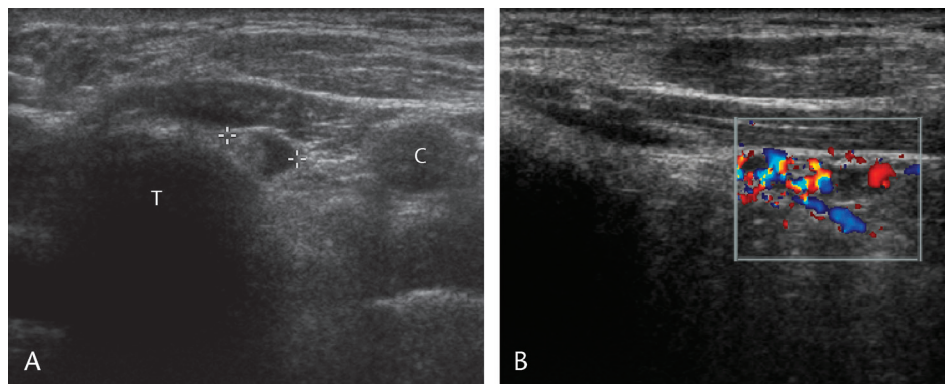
A 48-year-old man with a history of thyroidectomy for PTC 16 years ago and rising stimulated Tg levels. A, Transverse US of the left side of the neck, level VI, shows a $1.2 \times 0.4 \times 0.7$ hypoechoic mass adjacent to the trachea (T) (between calibers). C indicates common carotid artery. B, Sagittal Color Doppler US of the mass shows increased vascularity (arrow). The US-guided FNA of this mass yielded metastatic PTC.
